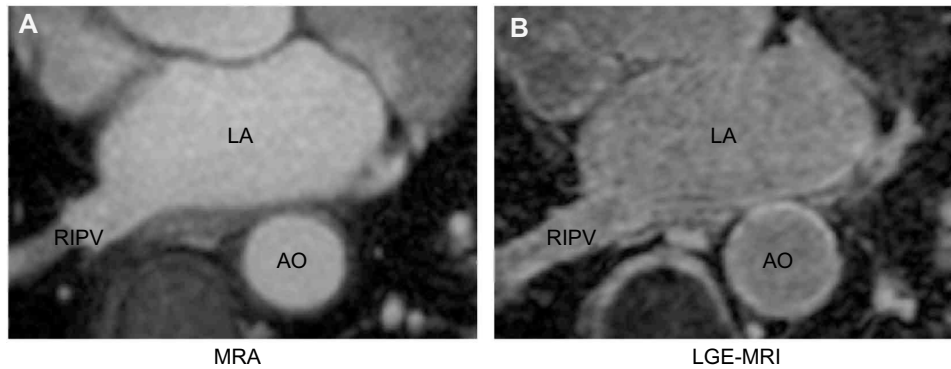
MRA and LGE-MRI of the LA. (A) A single slice from a 3D MRA sequence of the LA, showing the endocardial boundaries of the LA, the atrium of the RIPV, and the AO. (B) A co-registered slice from the subsequent 3D LGE-MRI sequence of the LA wall, showing enhancement in the LA wall.
